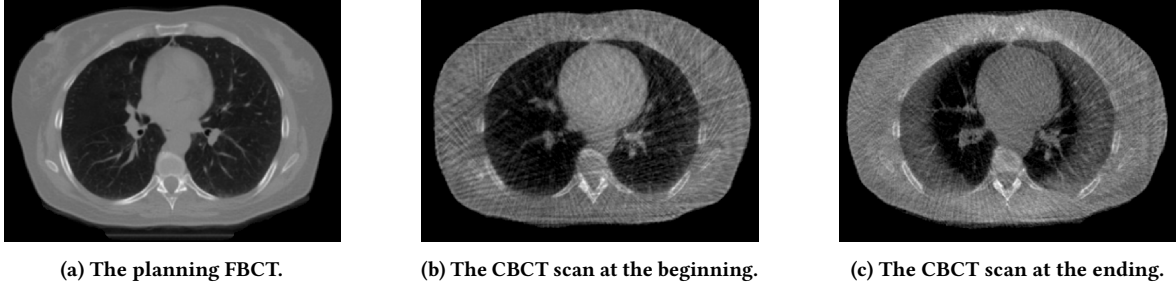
Example images from the ThoraxCBCT dataset.
